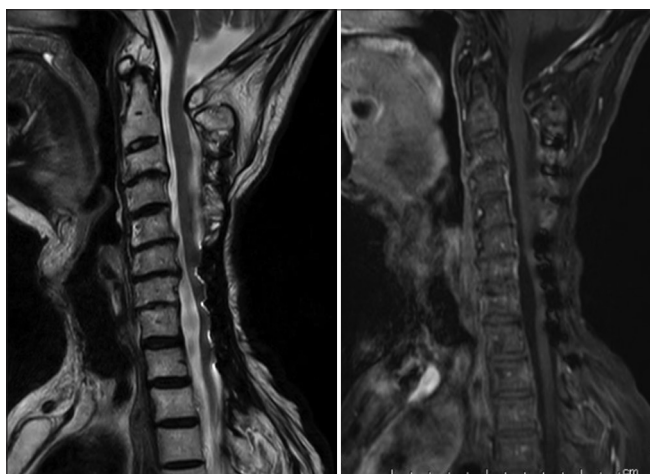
Follow-up MRI (3 years and 2 months after the surgery). Spinal edema and syringomyelia resolved. The recurrence of the tumor was not apparent (left: T2-weighted MRI; right: Gadolinium-enhanced T1-weighted MRI). MRI – Magnetic resonance imaging
